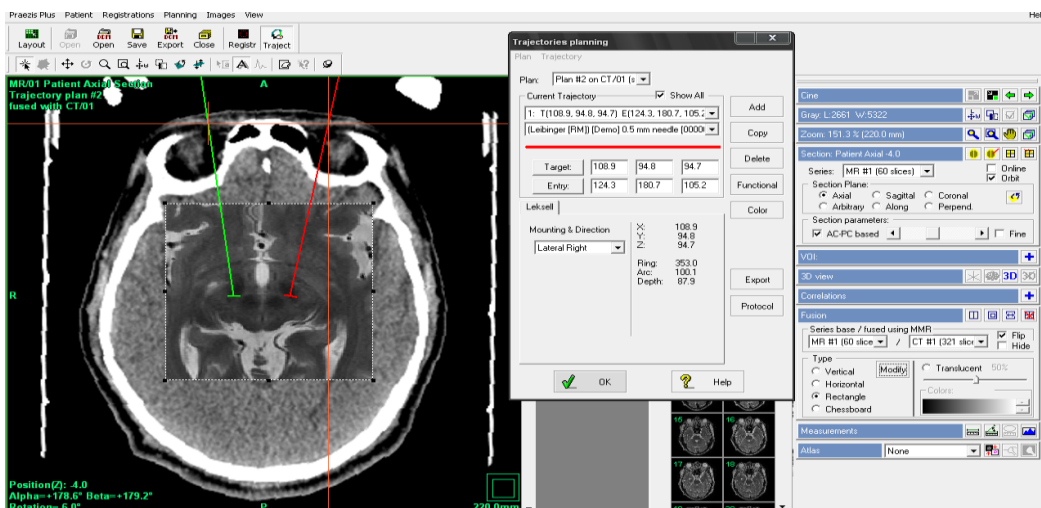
showing fusion of CT and MR image and STN is being targeted
